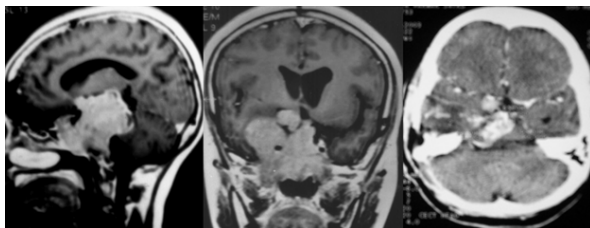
A case of right trigeminal schwannoma. Sagittal and coronal post contrast T1W images show a large homogeneously enhancing lesion with its epicentre in right cavernous sinus.. Axial post contrast CT image in the same patient.
